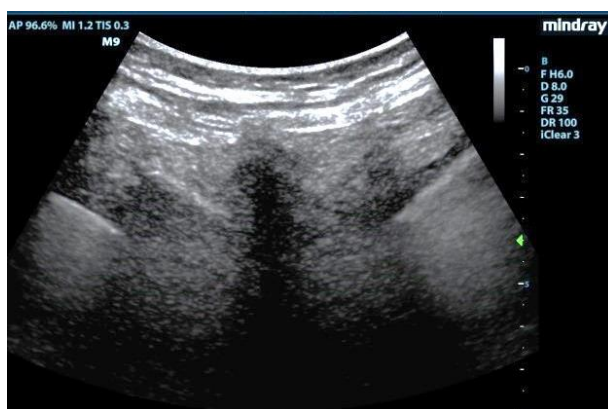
Ultrasound Image of the Real Human Thoracic Spine
